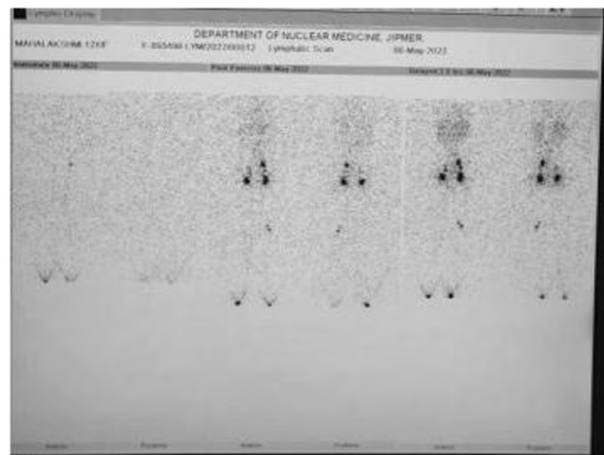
Lymphoscintigraphy of both lower limb
